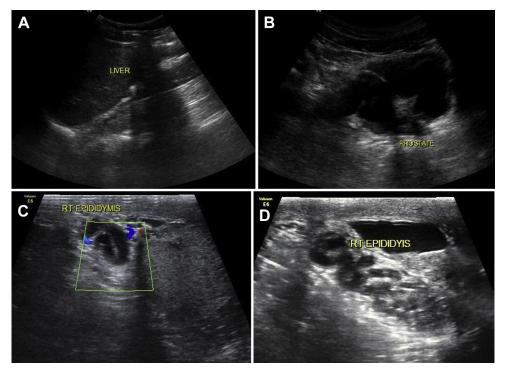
(A) Absent kidney in the right renal fossa. (B) Pelvic ultrasound shows cystic tubular structure posterior and to the right of the urinary bladder extending up to the midline. (C and D) Scrotal sonography image showing tubular dilatation in the head of epididymis with tortuous tubular nonvascular structures seen in the right spermatic cord.
